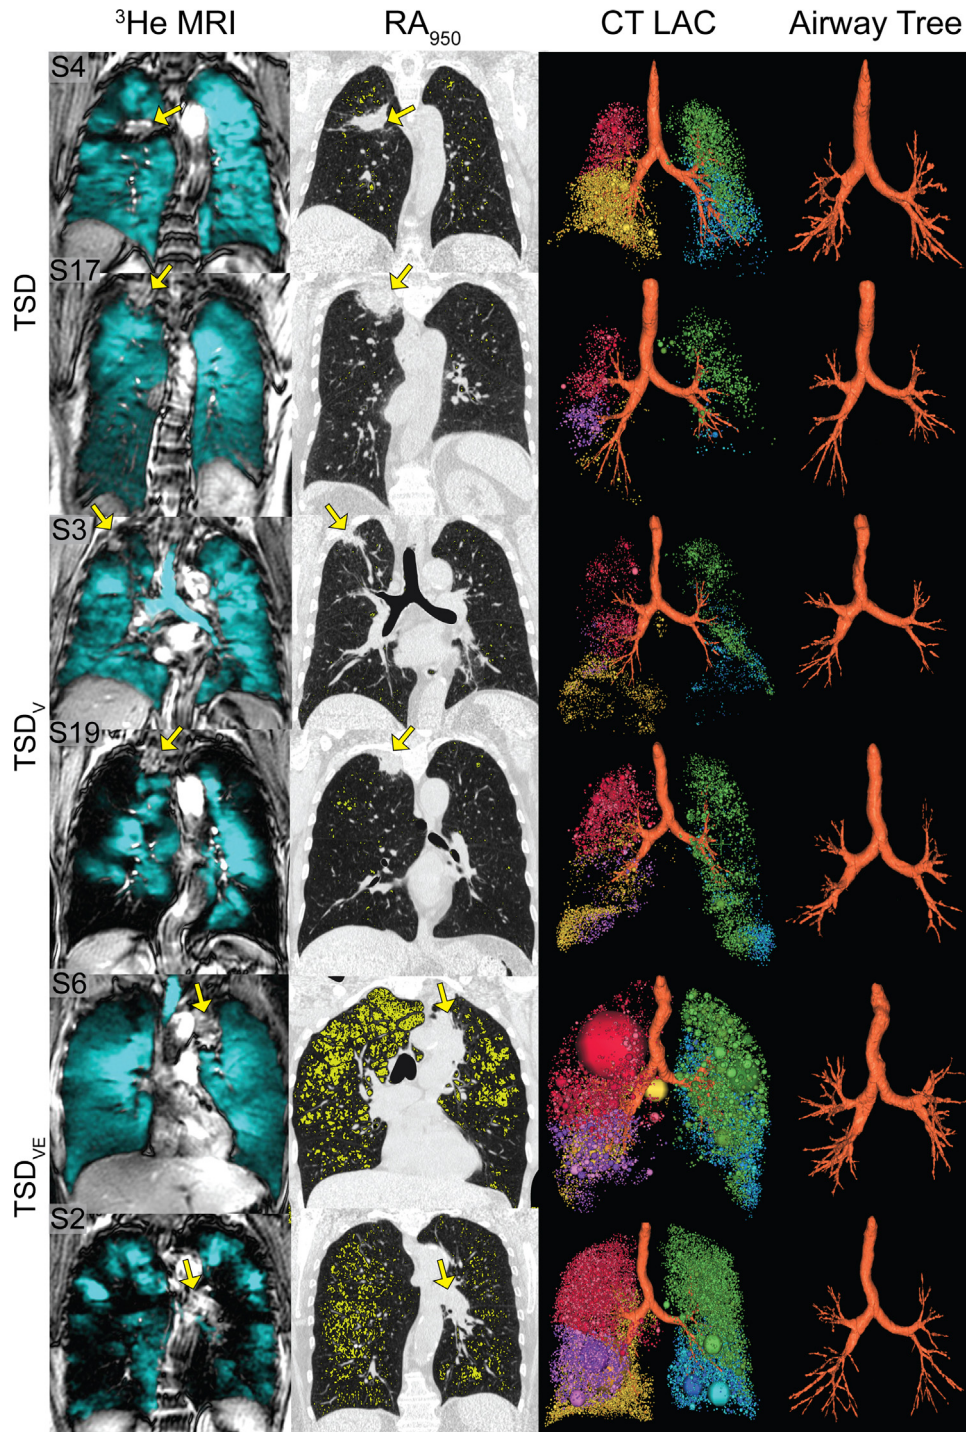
^3He MRI and CT for representative subjects with tumour-specific ventilation defects (TSD), tumour-specific and other ventilation defects (TSD_v), without emphysema, and tumour-specific and other ventilation defects with emphysema (TSD_{ve}) based on quantitative analysis. Left: ^3He MRI coronal static ventilation in blue co-registered to ^1H MRI. Middle: CT density masks where yellow = attenuation < -950 Hounsfield units (RA₉₅₀). Right: CT three-dimensional low-attenuation clusters (LAC), represented as spheres with CT densitometry values < -950 HU and CT three-dimensional reconstruction airway tree. Yellow arrows indicate tumour location. (For interpretation of the references to colour in this figure legend, the reader is referred to the web version of this article.)
